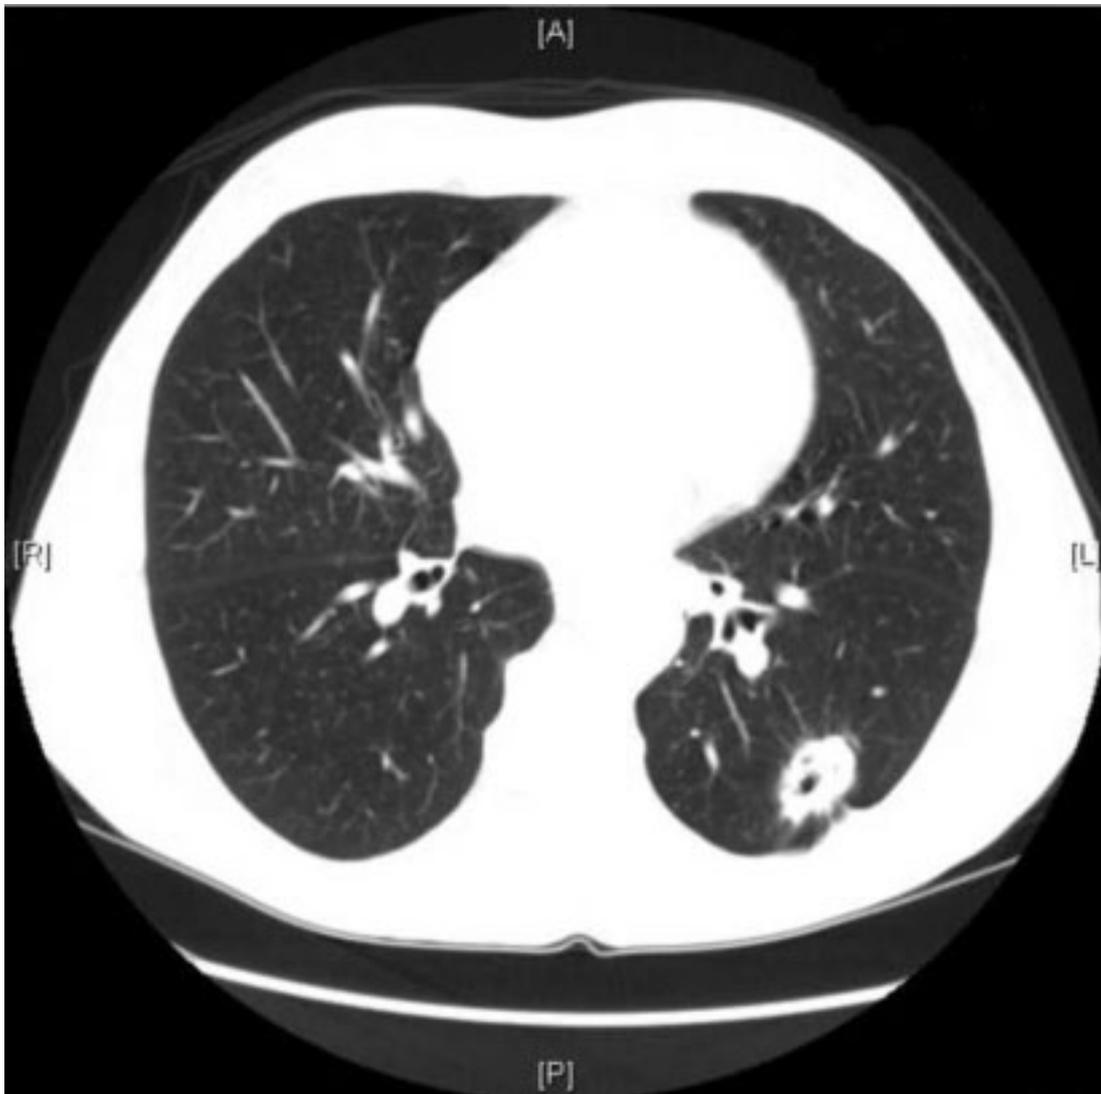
Chest CT scan showing a solid round-shaped abnormality with a diameter of about 20 mm at the apex of the left inferior lobule of the lung
